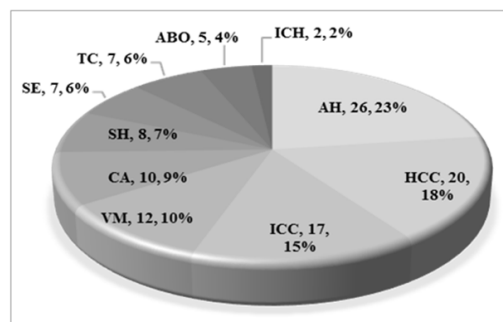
Brain abnormalities on computed tomography scan in children with cytomegalovirus infection
